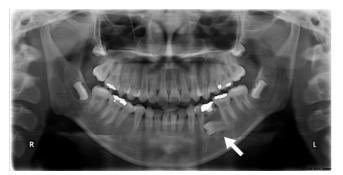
Preoperative panoramic radiograph of the 13-year-old female patient. The left mandibular second premolar was fully ectopically impacted, and the left mandibular second deciduous tooth was retained.
